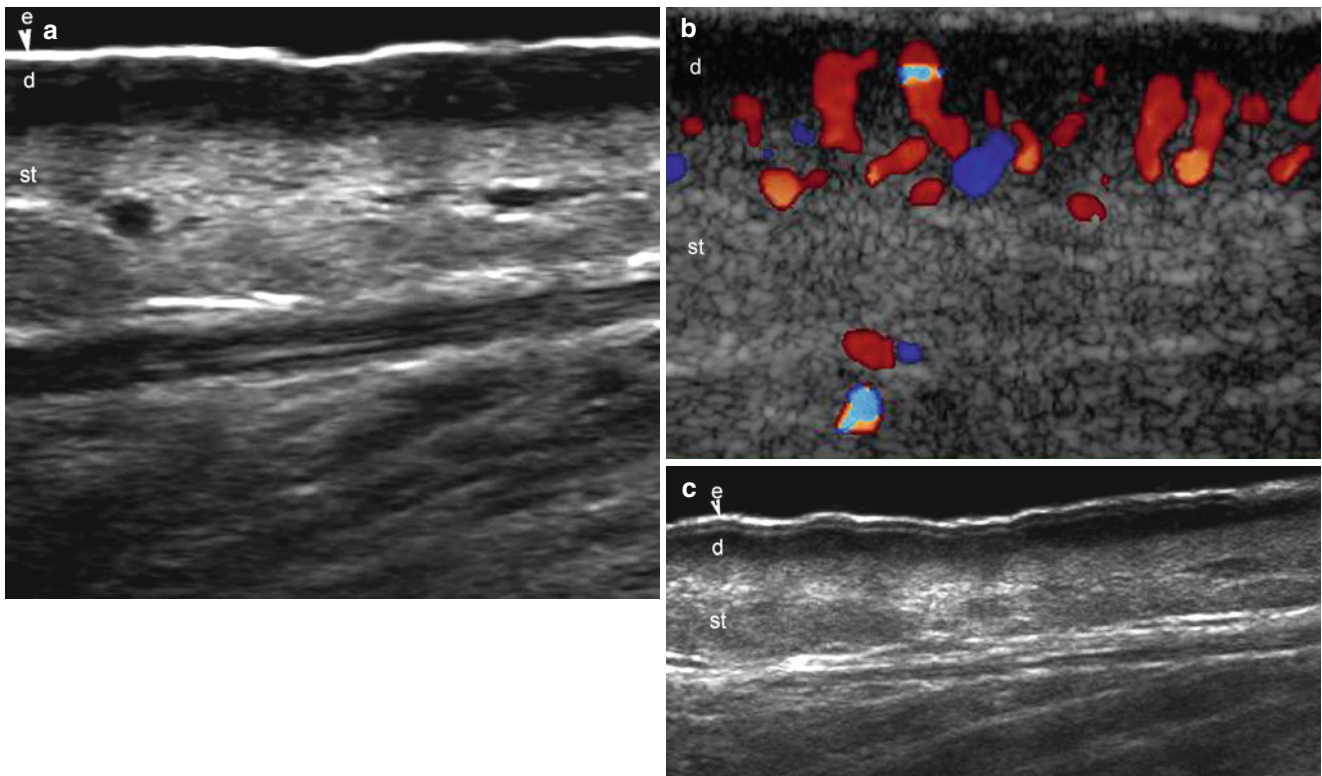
(a–c) Lymphedema. (a) Gray scale ultrasound image shows marked and diffuse hypoechogenicity of the dermis and increased echogenicity of the epidermis. (b) Color Doppler ultrasound image demonstrates increased vascularity in the dermis. (c) Extended field of view (gray scale)
